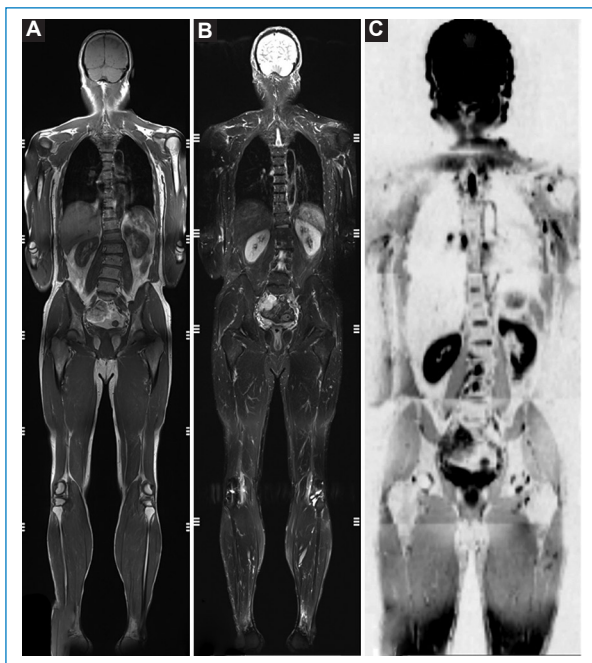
Whole body MRI protocol: coronal T1 whole body (A), coronal STIR (B) and coronal diffusion with inverted gray scale (C).
